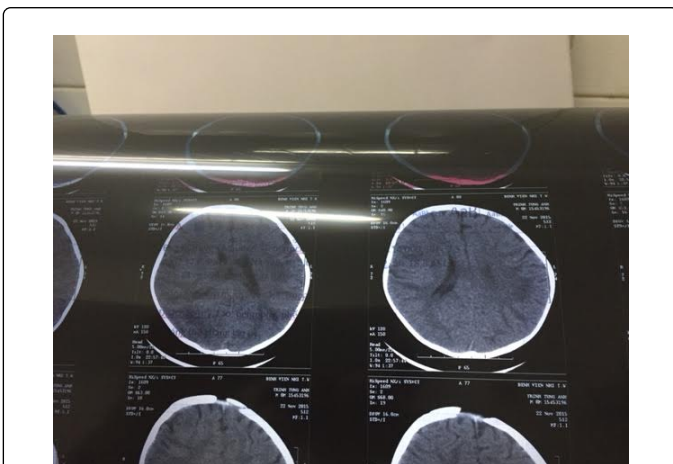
Cerebral edema in the CT scanner.
